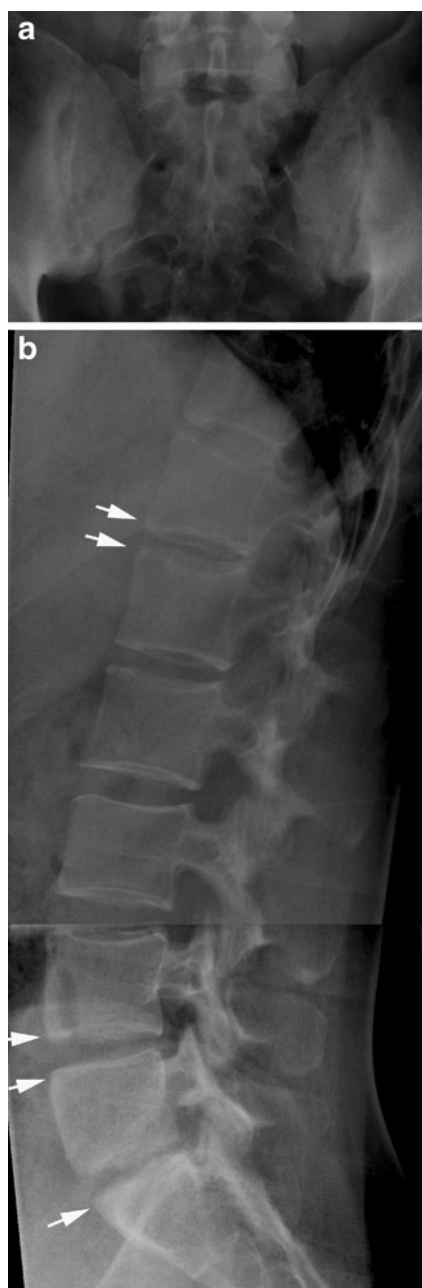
Relatively early changes in ankylosing spondylitis (AS). (a) AP radiograph of the sacroiliac joints in a 28-year-old man presenting with typical definite bilateral AS sacroiliitis (grade 3) in the form of bilateral joint erosion accompanied by subchondral sclerosis. (b) Initial spinal changes consisting of erosion of vertebral corners (Romanus lesion) with vertebral squaring corresponding to Th11, Th12, L4 and L5 accompanied by condensation of the vertebral corners—shiny corners (arrows)
